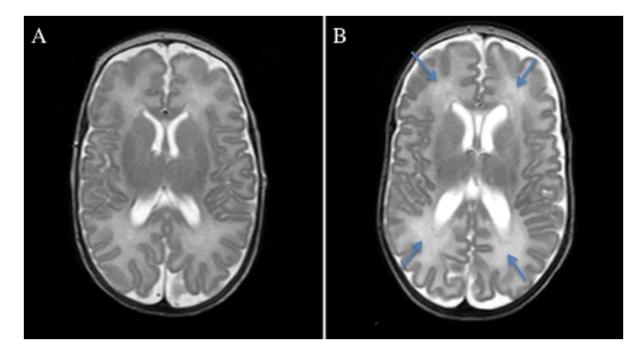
Axial T2-weighted MR images. Normal white and grey matter (A) and diffuse excessive high signal intensity (DEHSI) in the frontal and occipital white matter bilaterally (B). Blue arrows indicate the presence of DEHSI ¹¹³
